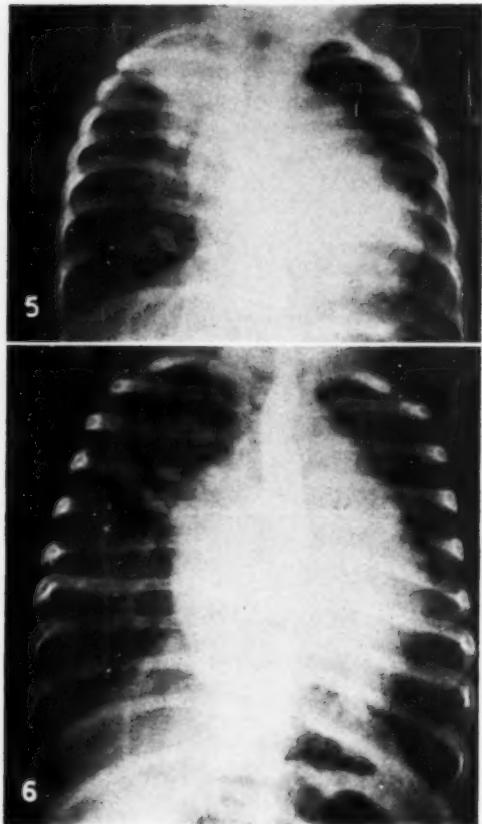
Case V. Roentgenogram at four months of age, three days prior to death, showing right upper lobe atelectasis with emphysema of the right middle and lower lobes. There is marked cardiac enlargement.
